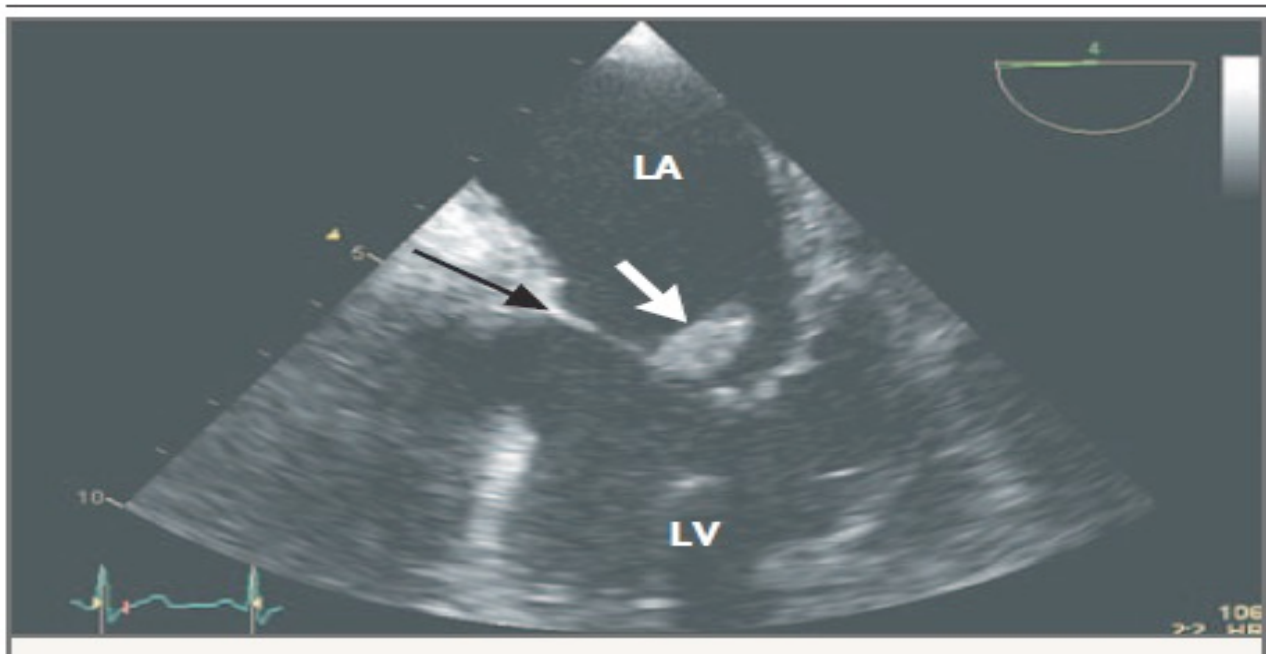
Transesophageal echocardiography showing a large vegetation on a native mitral valve
